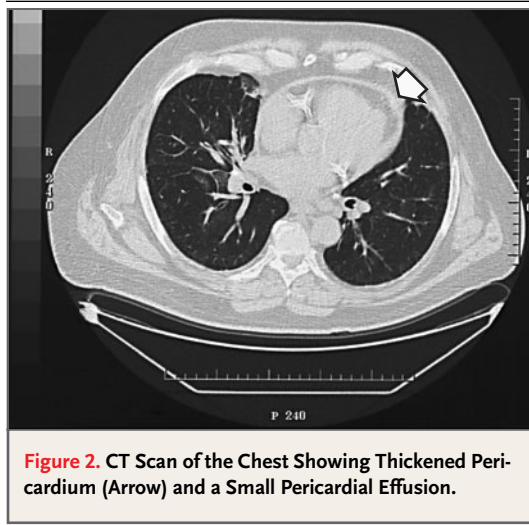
CT Scan of the Chest Showing Thickened Pericardium (Arrow) and a Small Pericardial Effusion.
